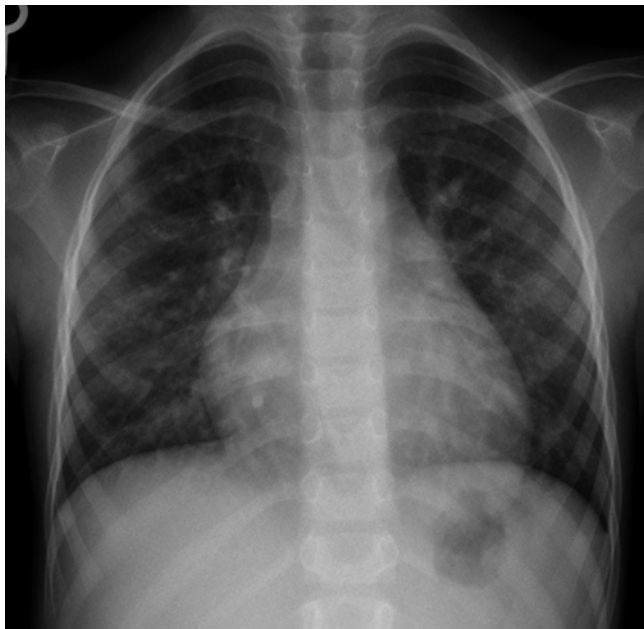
Chest radiograph of a patient with an ASD: Cardiomegaly and prominent pulmonary vascular markings are present
